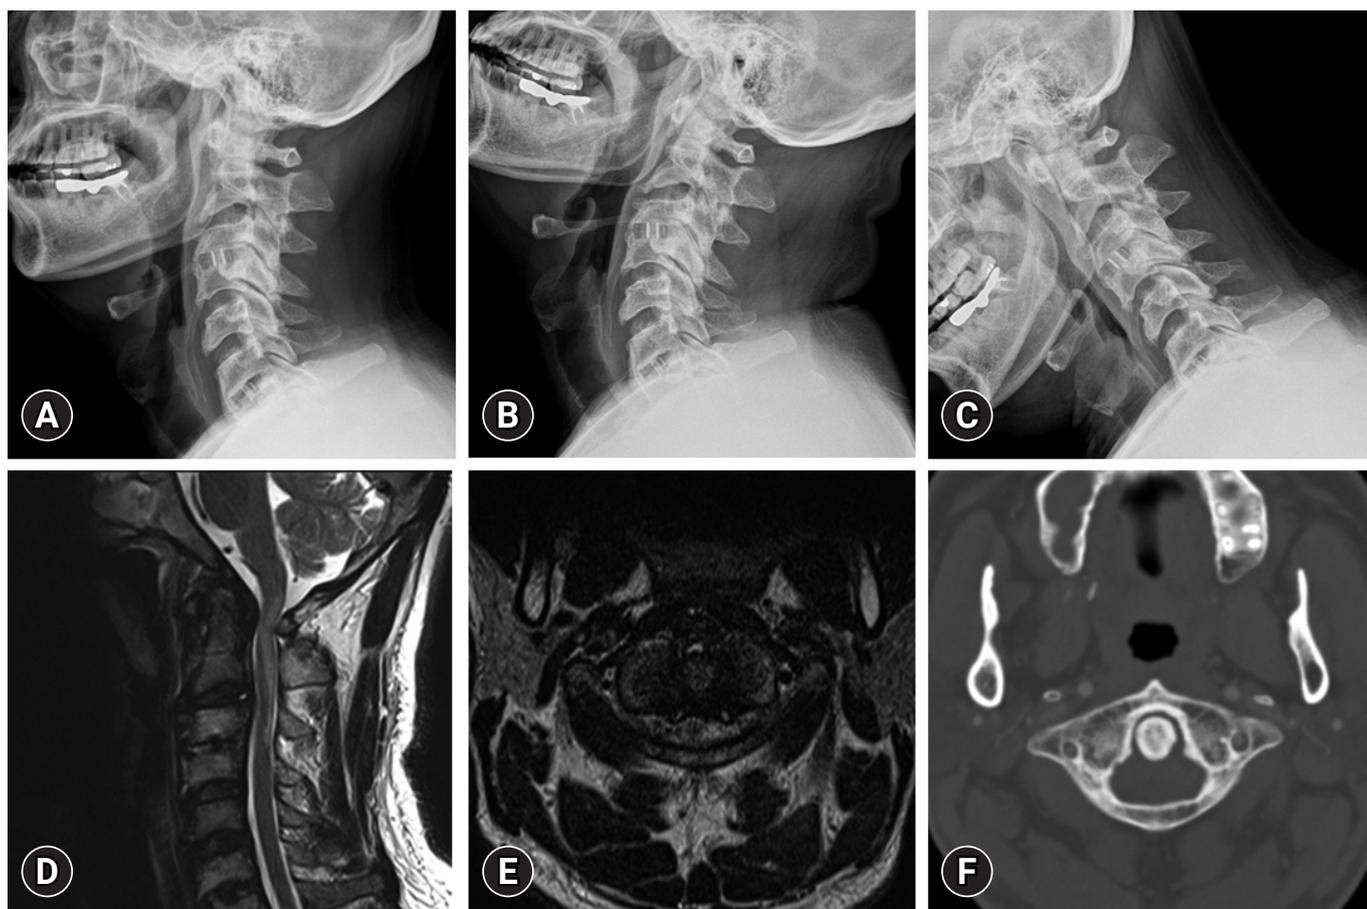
(A) Preoperative lateral cervical radiograph showing an atlantodental interval of 4 mm and arthrodesis at C3-4 and C6-7. (B, C) Preoperative dynamic views showing no atlantoaxial instability. (D, E) Preoperative T2-weighted magnetic resonance imaging showing spinal cord compression with high signal intensity due to a retro-odontoid pseudotumor. (F) Preoperative computed tomography scans showing no fracture of the anterior arch of the atlas.
